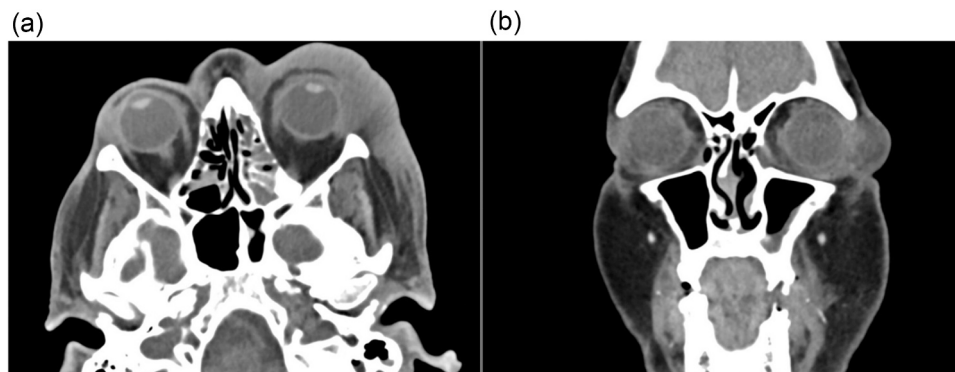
a: Computed tomography image demonstrating left-sided preseptal edema; b: Computed tomography image demonstrating left-sided preseptal edema (coronal).
